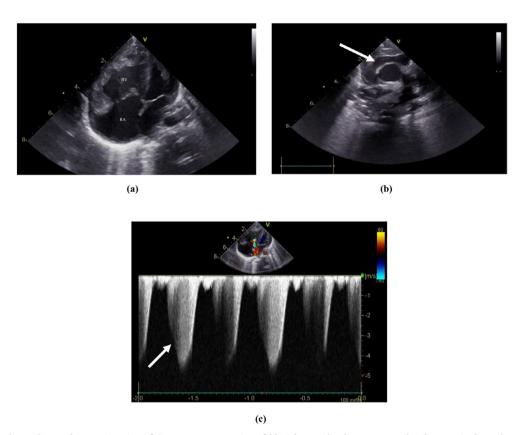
Echocardiography examination of Case 1, representative of (a) right atrial enlargement and right ventricular enlargement, (b) dilated superior vena cava (white arrow), and (c) tricuspid regurgitation in the Doppler view (white arrow). RA = right atrium; RV = right ventricle.
